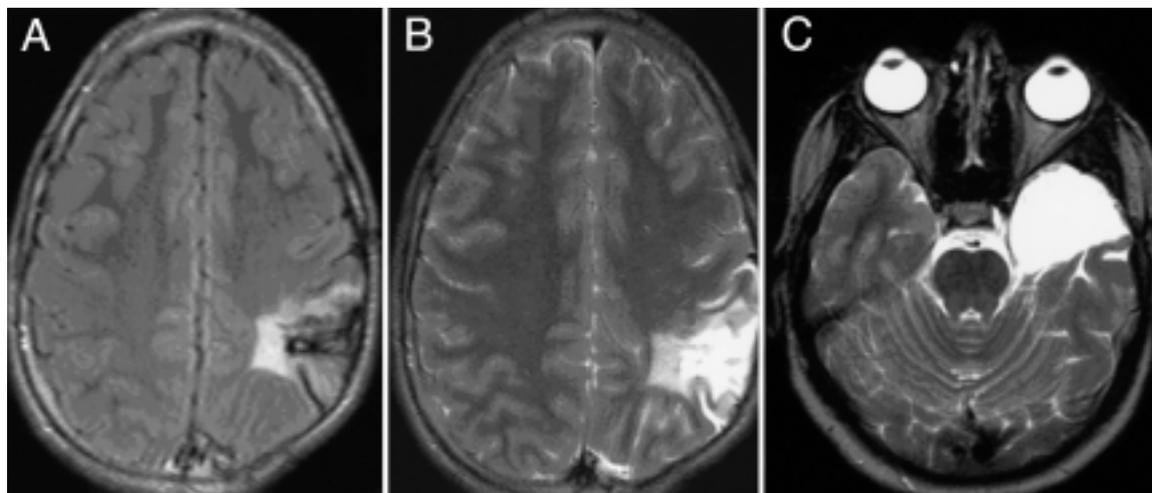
Magnetic resonance images obtained in two patients. Axial fluid-attenuated inversion-recovery image (A) and a T₂-weighted image (B) showing a hyperintense signal (T2HI) around the tumor cavity in a patient with uncontrolled seizure. Absence of a hyperintense signal around the tumor cavity on T₂-weighted imaging in a patient with controlled seizures (C).
